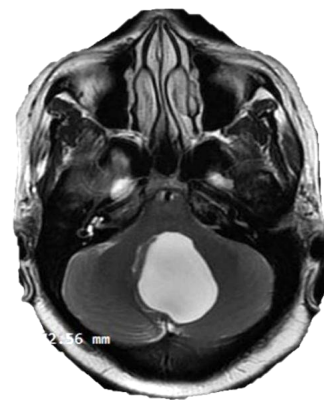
T2-weighted MRI Scan showing a hyperintense lesion in the posterior fossa
